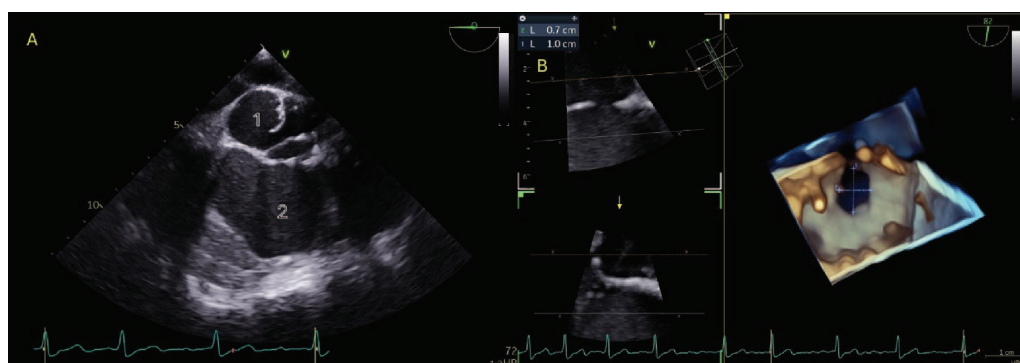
A) Transesophageal echocardiography image of aortic pseudoaneurysm (1 – aortic root; 2 – pseudoaneurysm). B) One of the communications of the pseudoaneurysm with the sinus of Valsalva, measuring 7x10 mm.
